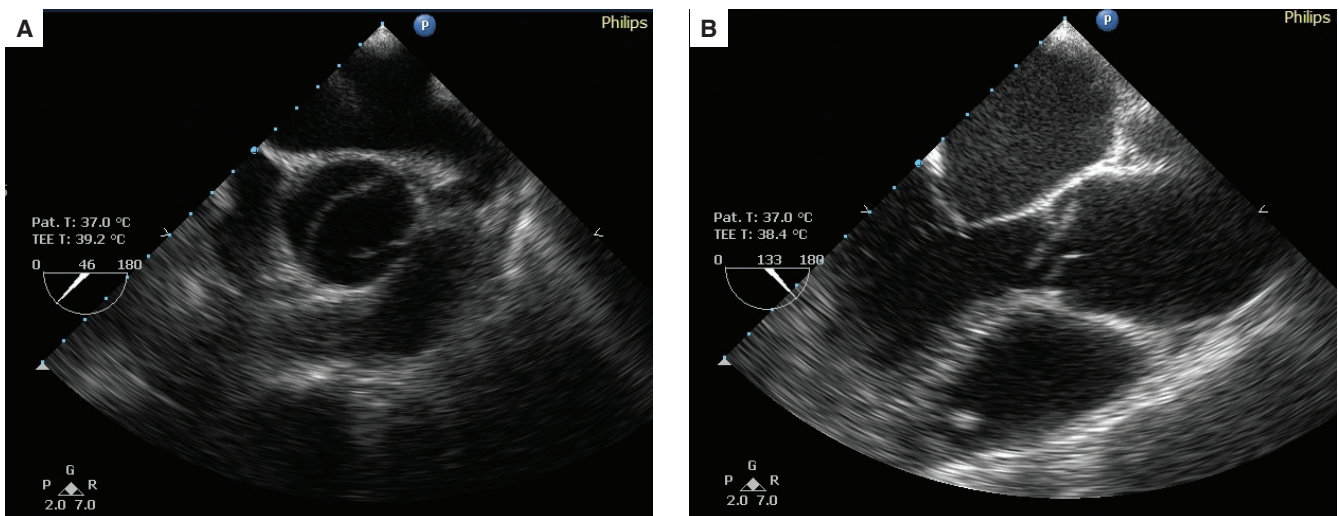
A. Transoesophageal echocardiography depicting the bicuspid aortic valve. B. Transoesophageal echocardiography demonstrating an accessory valve-like structure 2 cm above the aortic valves. Findings were suggestive of an atypical form of aortic dissection in the patient with a bicuspid aortic valve.
